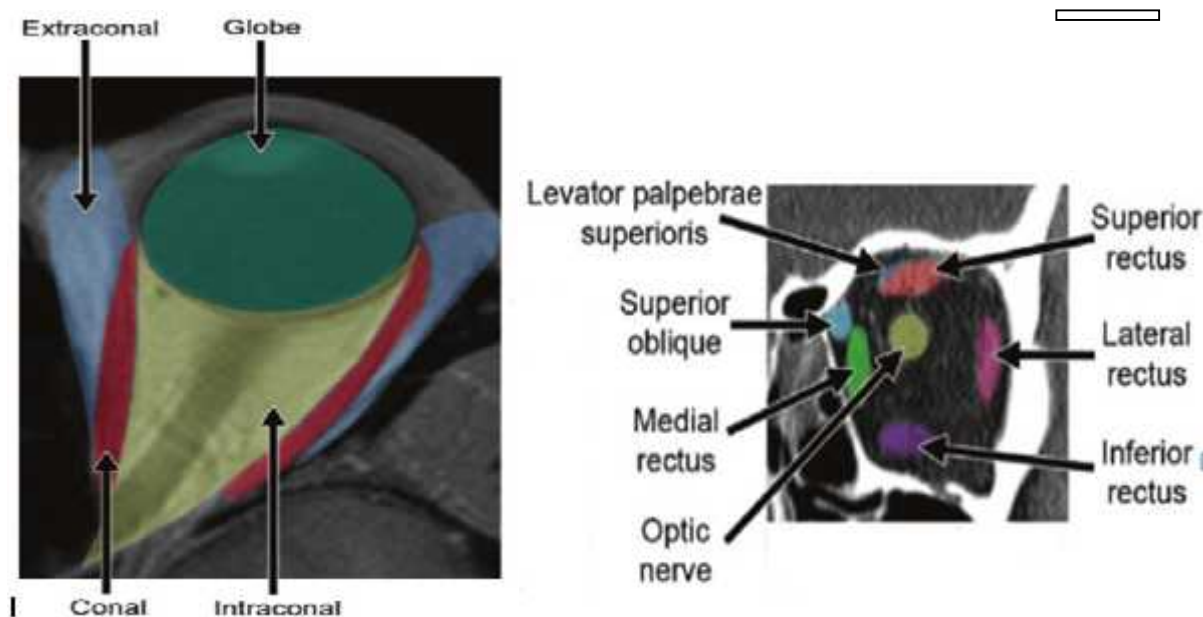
Normal orbital anatomy. Axial CT image (left) with color overlays shows the orbit divided into intraocular and extraocular spaces by the muscle cone. Coronal CT images (right) with color overlays show the configuration of the extraocular muscles.[2]
